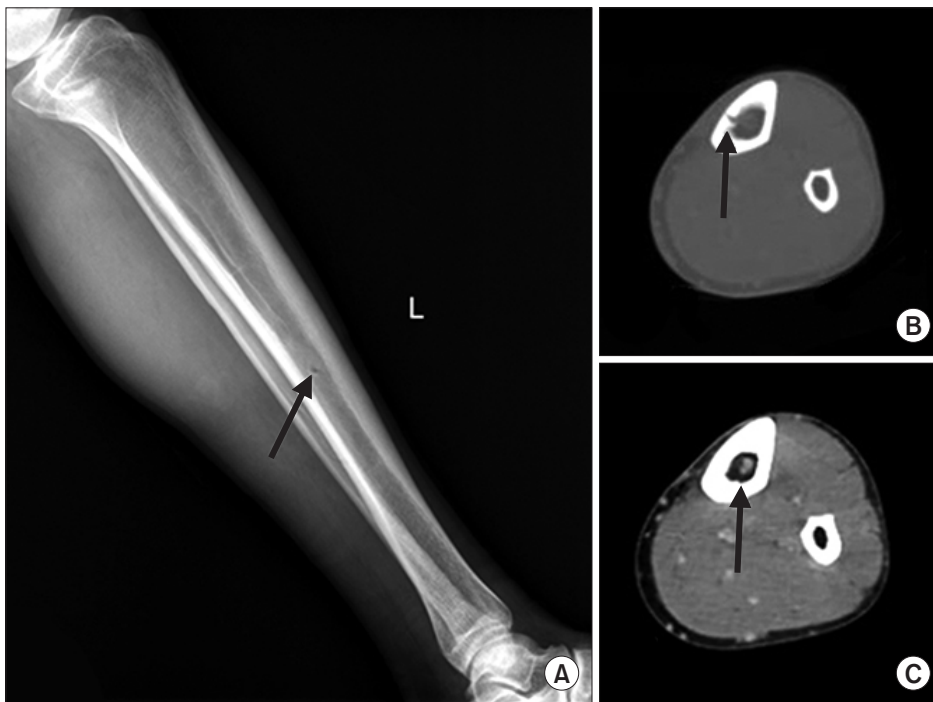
(A) Simple radiography revealed a cortical bone defect in the tibia (arrow). (B, C) Computed tomography showed a tibial opening and an intraosseous vascular cluster (arrow).
